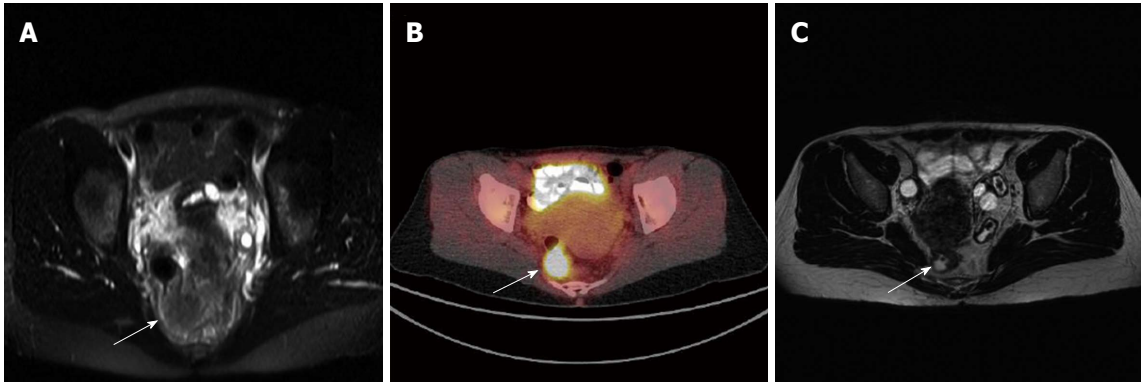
Initial rectal cancer staging of a 48 year old female. A: Occlusion of the rectum by solid tumor on magnetic resonance imaging (MRI) (arrow); B: Corresponding high Fluorodeoxyglucose metabolism in the Fluorodeoxyglucose positron emission tomography/computed tomography; C: Post treatment (chemoradiation therapy) magnetic resonance imaging shows a clear tumor size reduction (arrow) with a continuing lumen after chemoradiation therapy.
